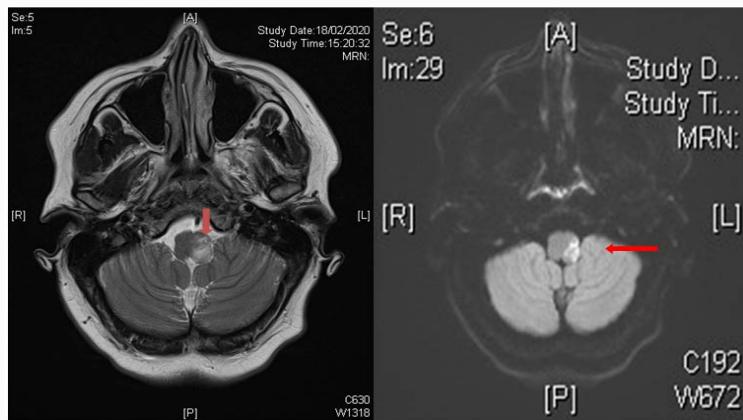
MRI Brain was done and Showed left lateral aspect of the medulla oblongata due to an acute infarction.
